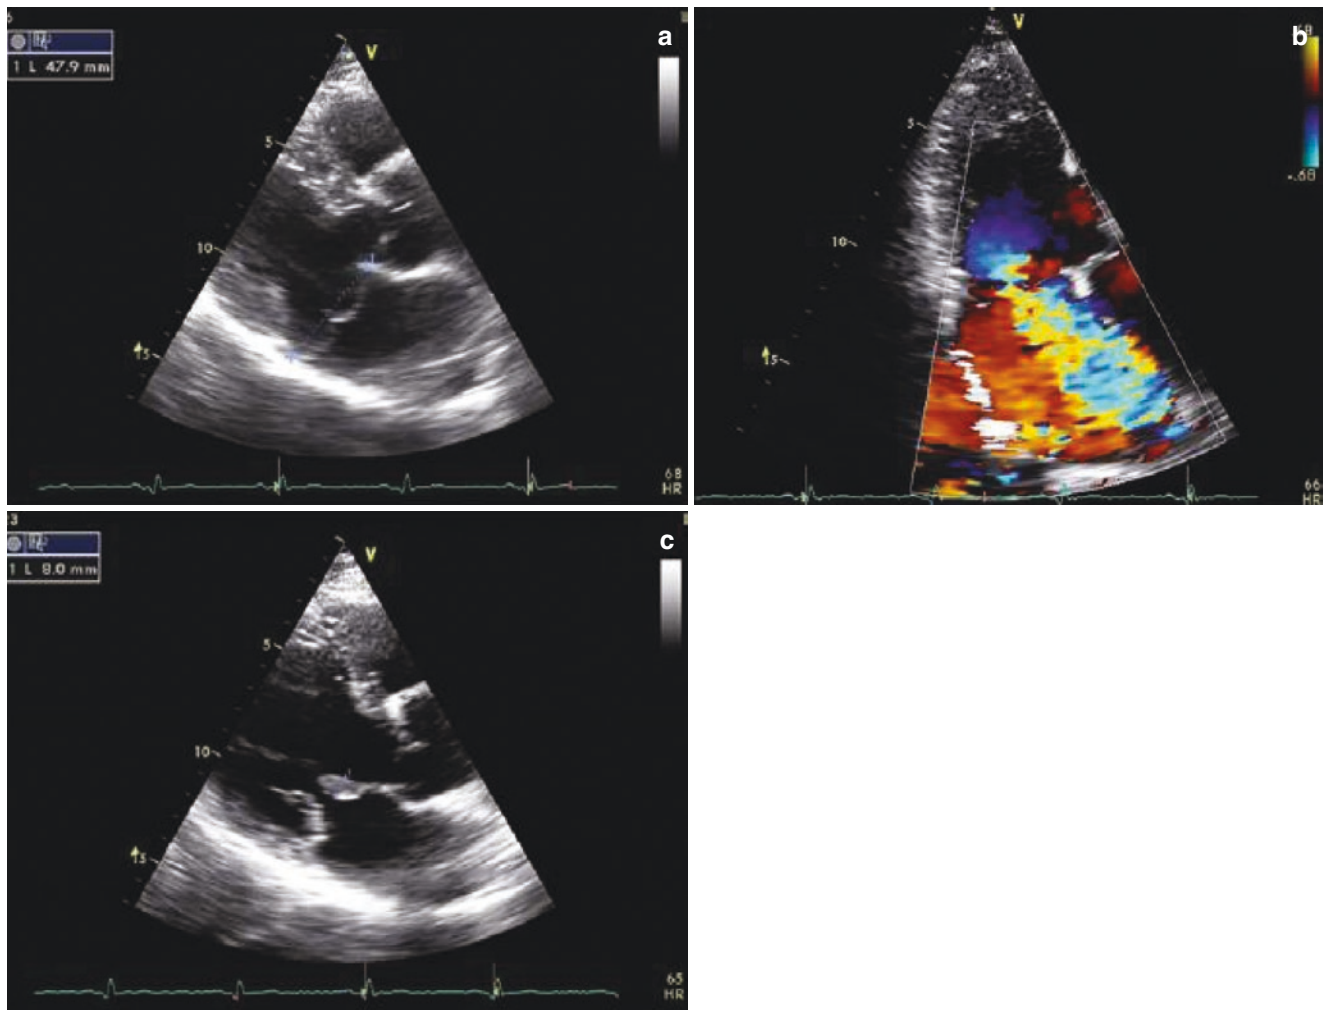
(a) Parasternal long axis echocardiography showing classical mitral valve prolapse. Both posterior and anterior myxomatous mitral valve leaflets are billowing up to 6.5 mm in the left atrium during systole. (b) Apical three-chamber echocardiography with color Doppler
